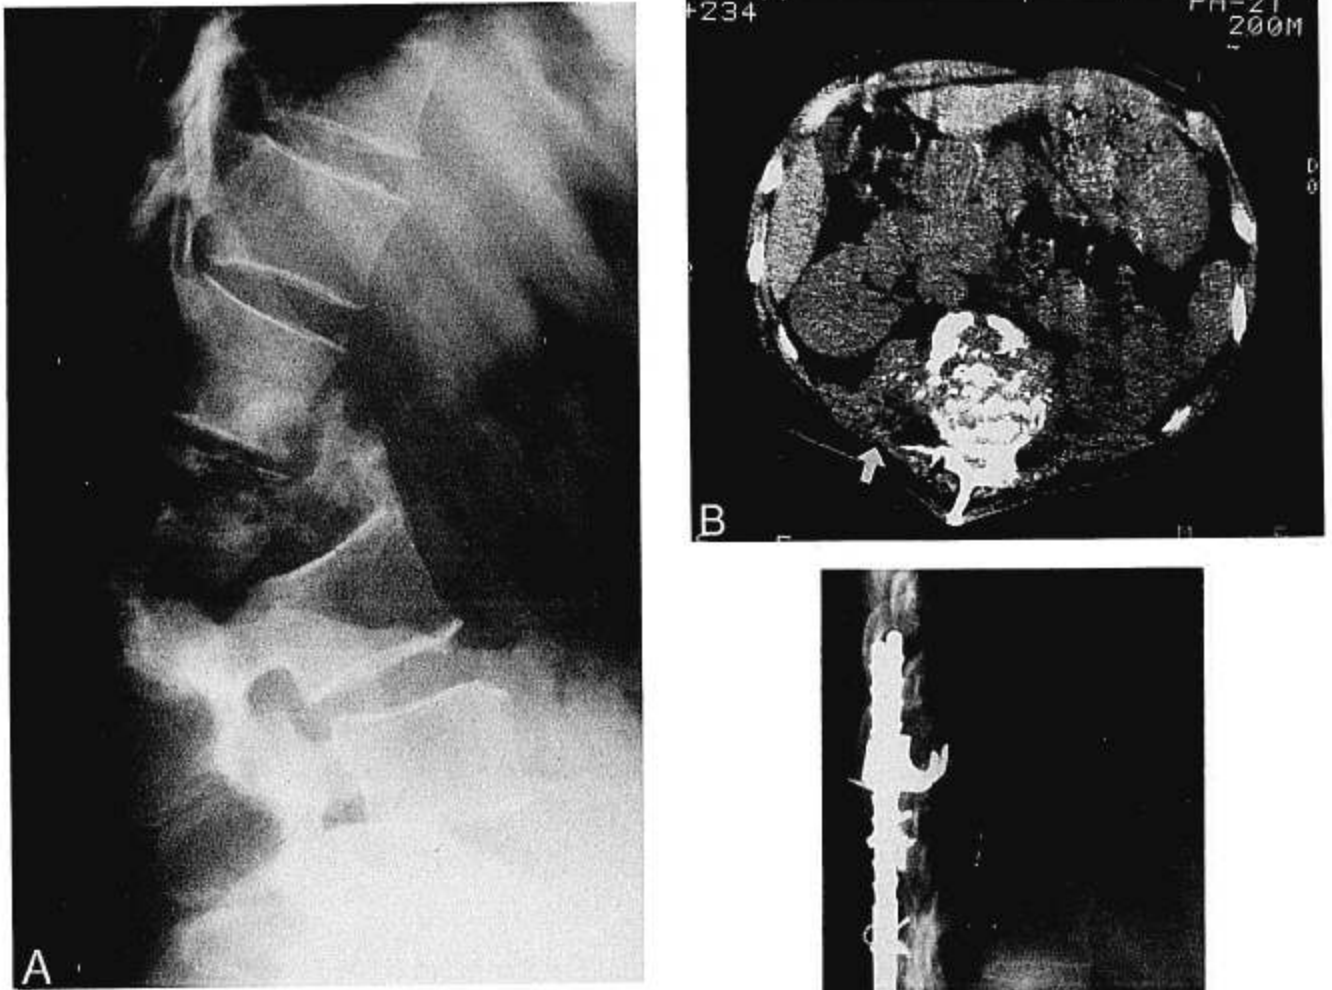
A 47-year-old woman with tuberculosis from L1 to L3. A, Roentgenogram showing a destructive vertebral lesion (L1, L2) and severe kyphotic deformity. B, Computed tomography of L2. Bilateral paravertebral abscesses, destruction of the vertebral body and bilateral pedicles are seen. A soft tissue abscess extends dorsally (arrow). C, Radiograph made 7 years after one-stage anterior and posterior fusion with correction of kyphosis. There is bone fusion from T12 to L3.
